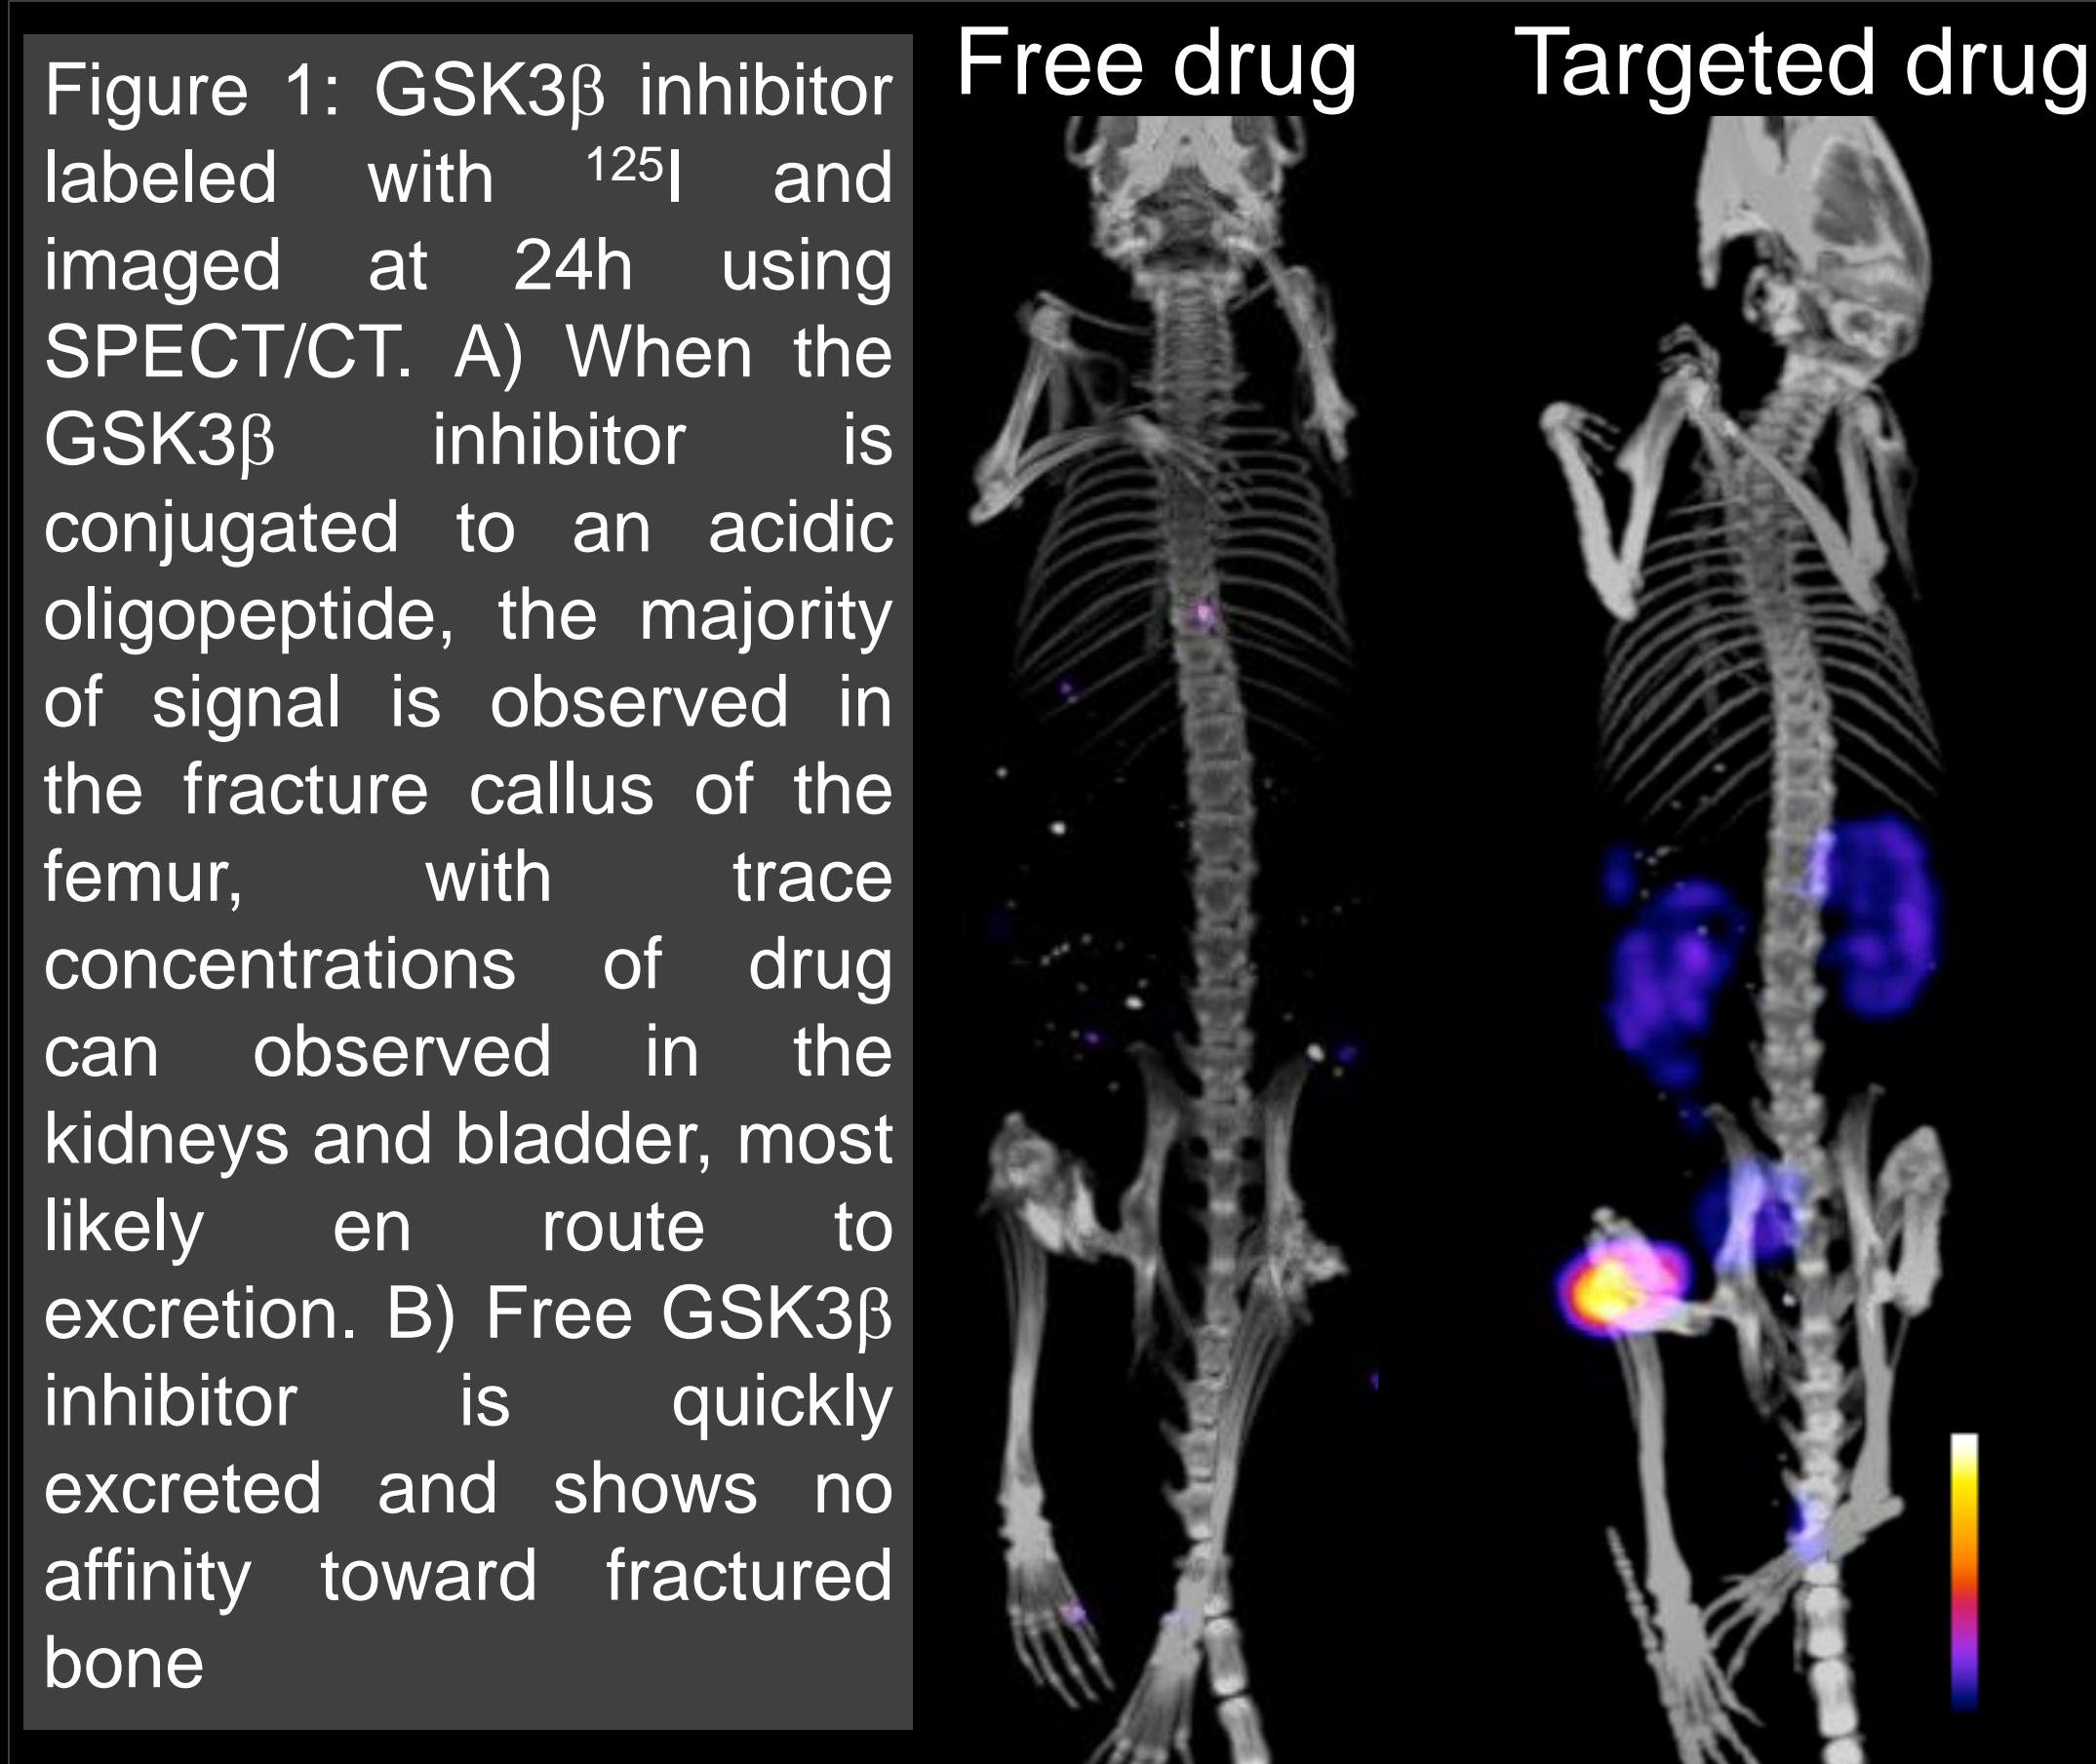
GSK3 β inhibitor labeled with ¹²⁵I and imaged at 24h using SPECT/CT. A) When the GSK3 β inhibitor is conjugated to an acidic oligopeptide, the majority of signal is observed in the fracture callus of the femur, with trace concentrations of drug can be observed in the kidneys and bladder, most likely en route to excretion. B) Free GSK3 β inhibitor is quickly excreted and shows no affinity toward fractured bone
